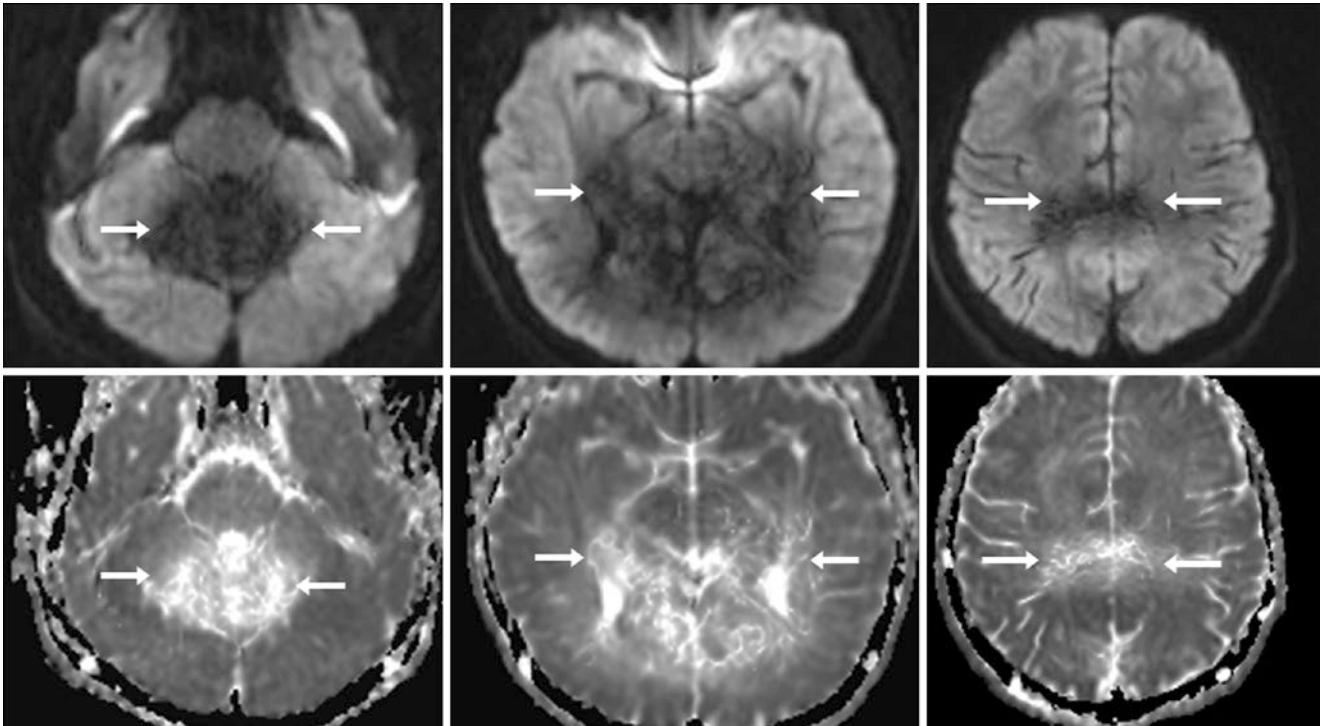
An 11-year-old with a large region of dark artifact from eddy currents or mechanical vibration (*arrows*), as shown on DWI at 3 T (*top row*), with bright signal on ADC maps (*bottom row*). FLAIR and T2WI were normal (*not shown*)
